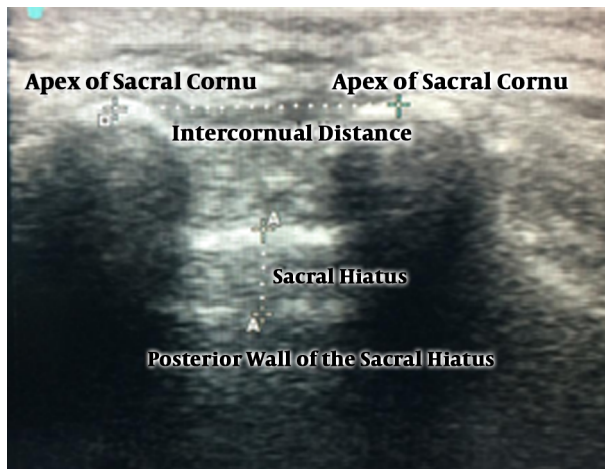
Ultrasound image of the sacral hiatus. The intercornual distance between bilateral cornua was measured between the apexes of both cornua on a transverse image.
